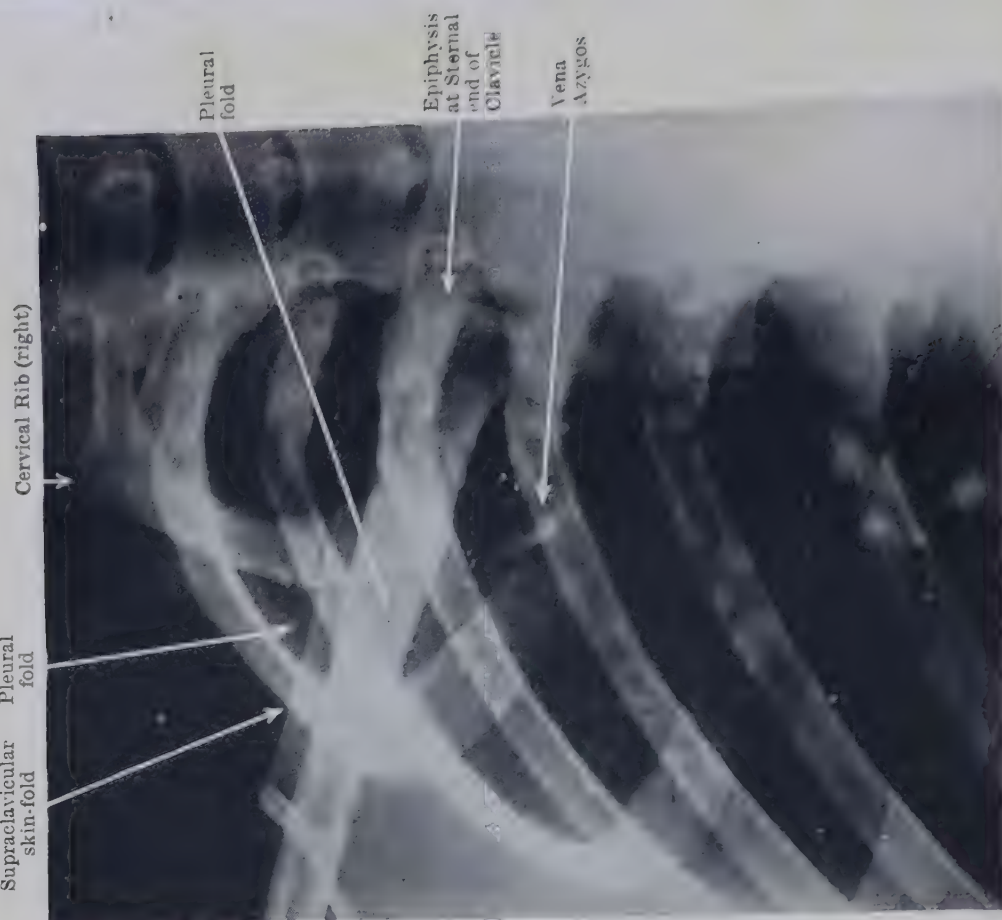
RADIOGRAPH OF RIGHT CERVICO-THORACIC REGION, OF WOMAN AGED 35, SHOWING, IN ADDITION TO CERVICAL RIB, THE SHADOWS OF VENA AZYGOS AND PLEURAL FOLD THAT INDICATE THE PRESENCE OF A "LOBE OF THE VENA AZYGOS" IN THE RIGHT LUNG.
